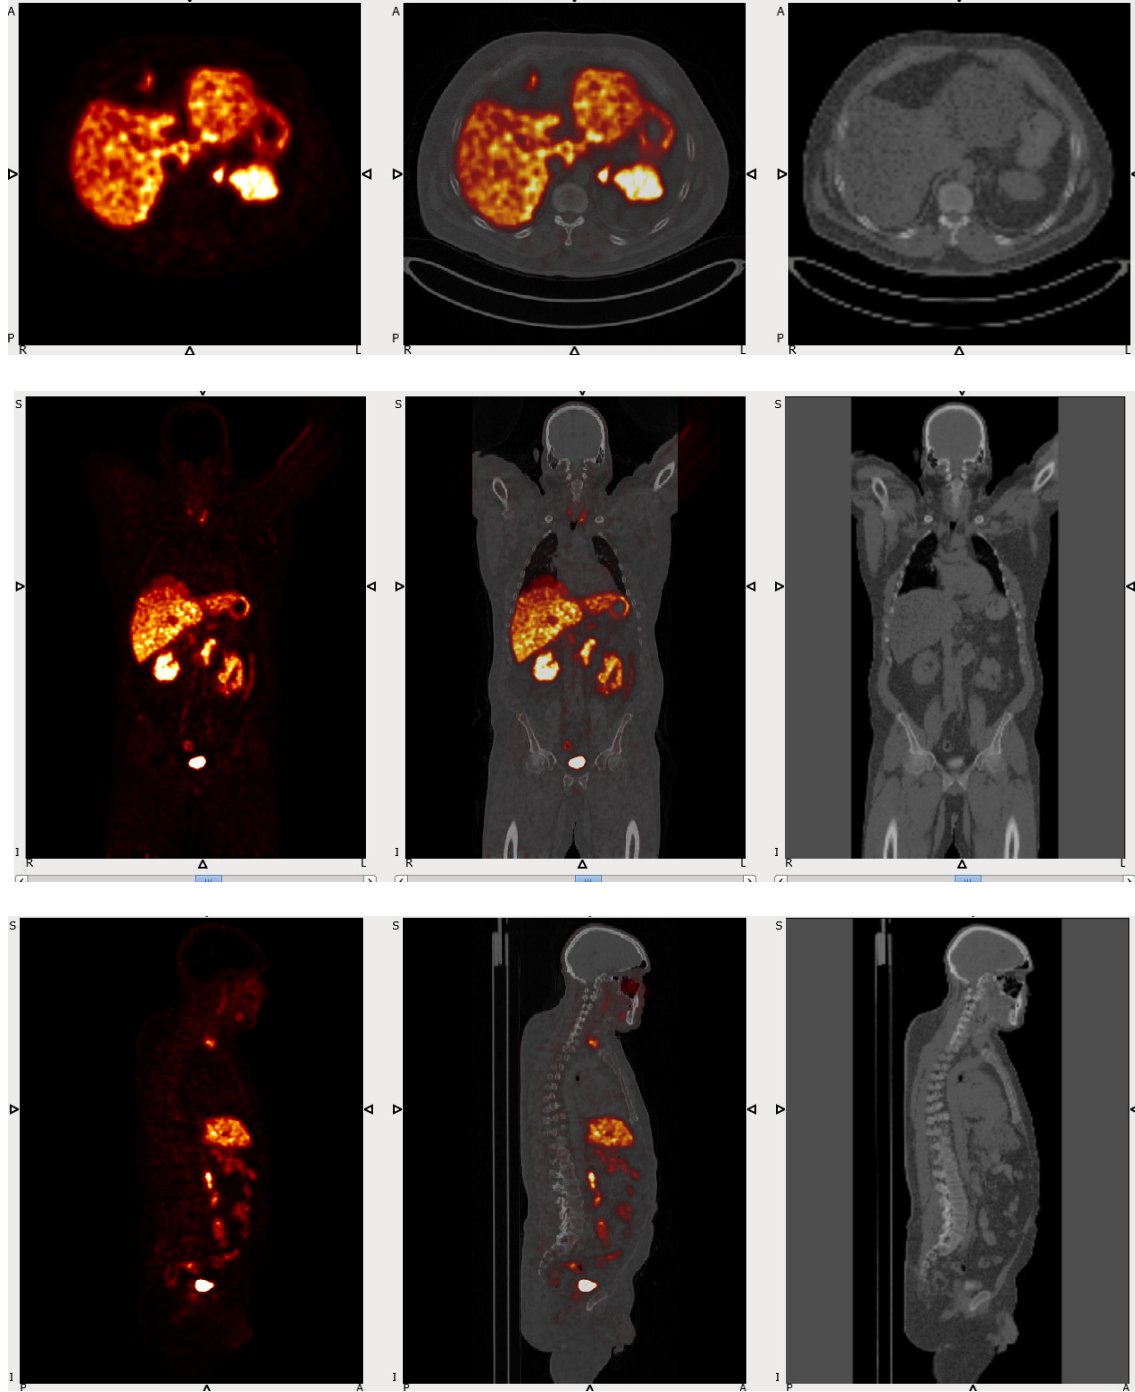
18:  $PET_0$  (first column),  $PET_0/CT$  (second column) and generated attenuation map (third column) according to Appendix J. The first row is axial, the second row is coronal, and the third row is sagittal views for patient 12, where the  $PRC_5$  was free from artefacts.
